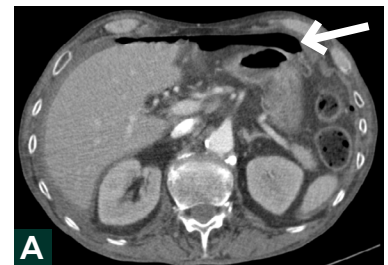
Abdominal CT scan showing pneumoperitoneum (white arrow).
